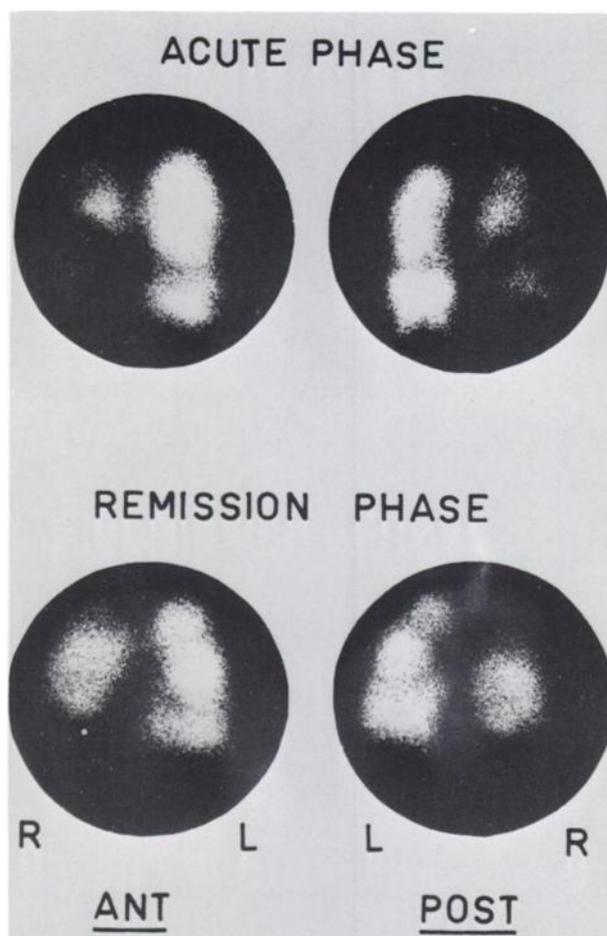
Two scintigraphic studies at 1-month interval. First study performed during acute phase; on second study obtained during remission phase, there is striking improvement in lesions.
